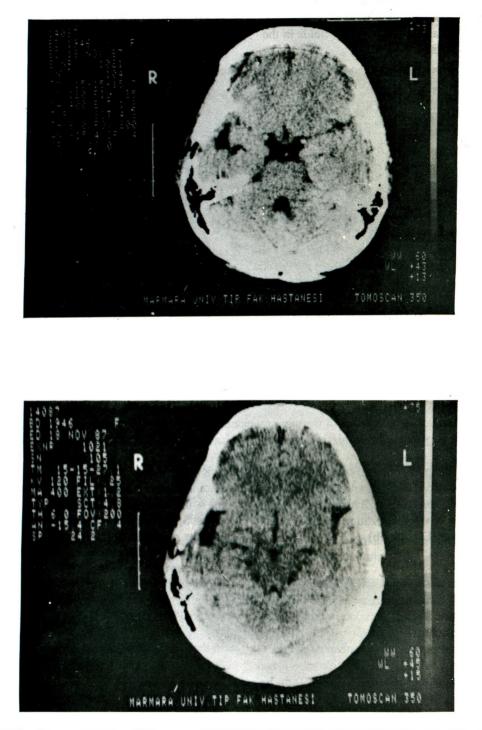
Six months later, CT scan revealed right temporal atrophy at the resection site of the mass.
